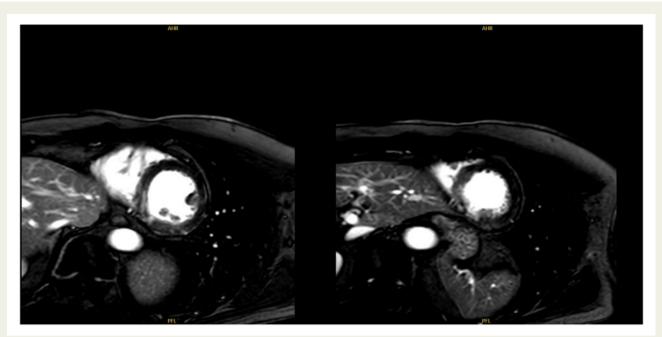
Cardiac magnetic resonance imaging in the short-axis view sequences demonstrate near patchy late gadolinium enhancement with focal areas of transmural involvement at the left circumflex artery territory consistent with myocardial infarction.
